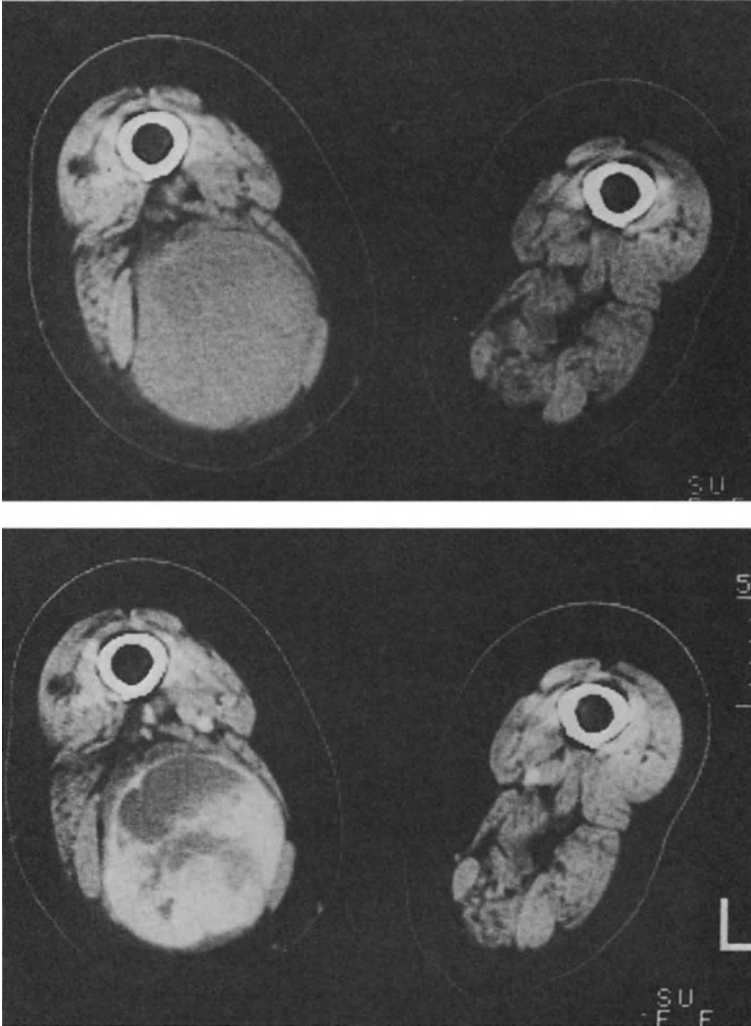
CT pattern; tumor necrosis. A: Nonenhanced CT-scan. A homogenous mass is present in the right semimembranosus muscle. B: After i. v. contrast administration, nonenhancing areas are clearly outlined, which on subsequent biopsy were found to represent necroses.
